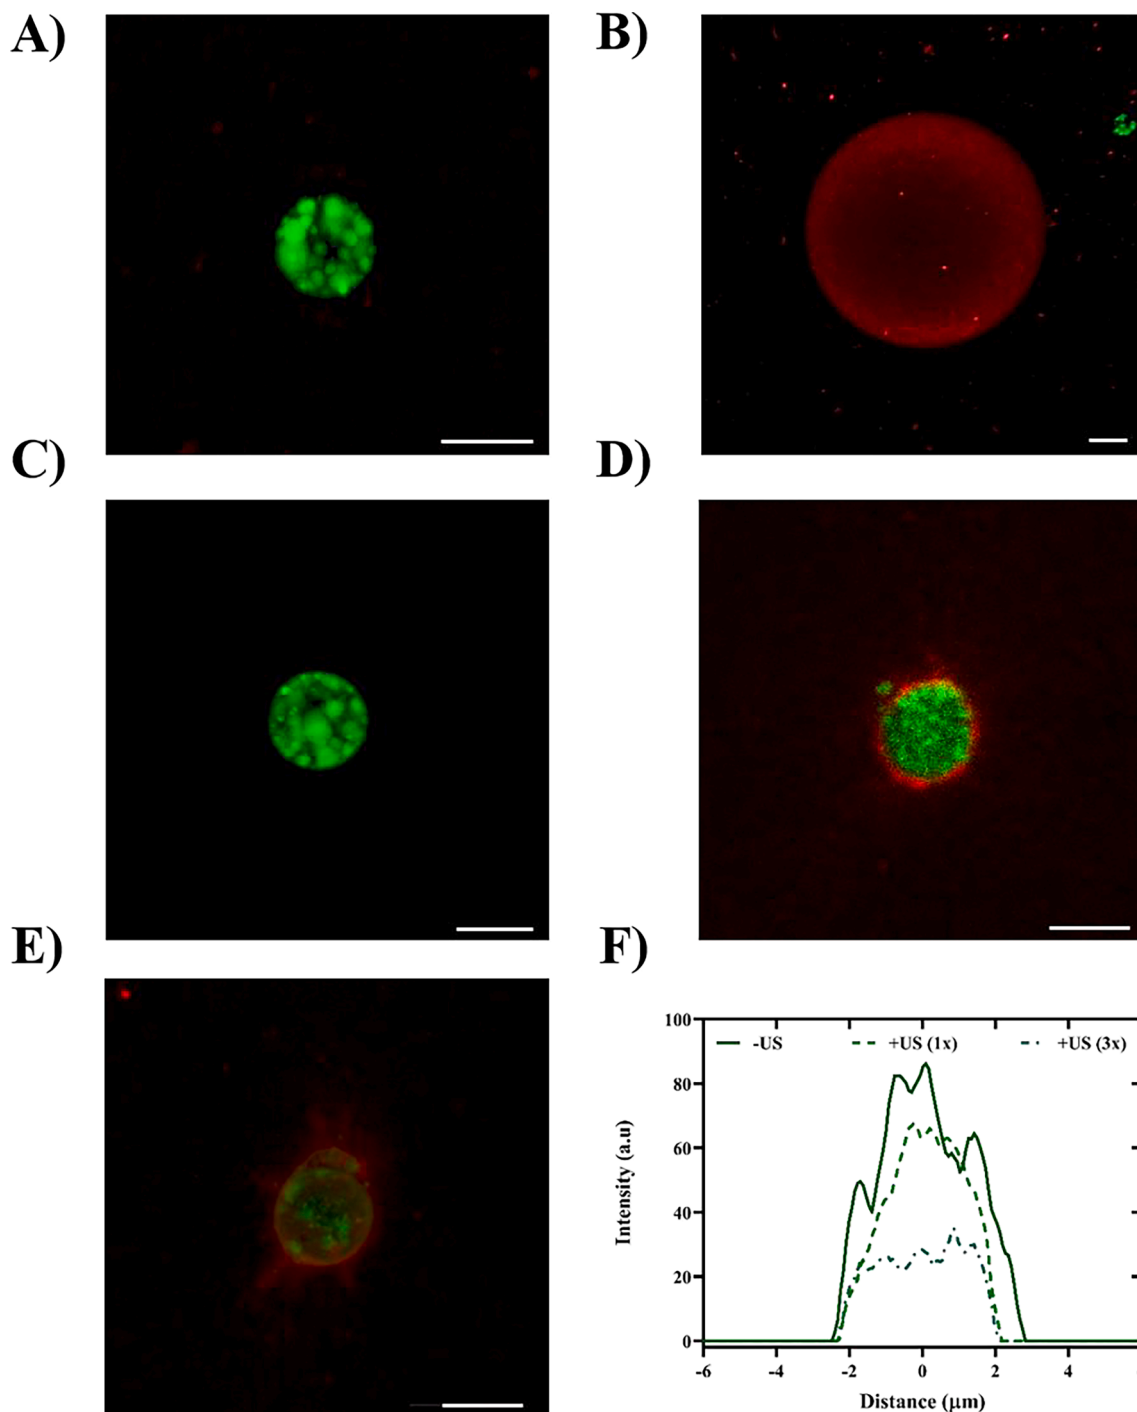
Acoustic droplet vaporization (ADV) in acoustically-responsive scaffolds (ARSs) resulted in stable bubble formation in sufficiently-sized perfluorohexane (PFH) emulsion and transient bubble formation in perfluorooctane (PFO) emulsion at 2.5 MHz (pulse duration: 5.4 μs). (A) Maximum intensity projection of confocal z-stacks of an ARS containing PFH emulsion. The fibrin matrix contained Alexa Flour 647-labeled fibrinogen (shown in red) while the phase-shift double emulsion contained Alexa Flour 488-labeled dextran (AF₄₈₈, shown in green). (B) ADV resulted in stable bubble formation in ARSs containing PFH emulsion. ARSs with PFO emulsion (C) before and (D) after ADV behaved differently (no stable bubble formation). Similar acoustic settings were used in (B) and (D). (E) Repeated ultrasound (US) exposures (3x) in ARSs with PFO emulsion resulted in more AF₄₈₈ release, thus indicating repeated vaporization and recondensation during US pulses. AF₄₈₈ intensity measurements, comparing payload release from PFO over multiple US exposures, is shown in F. Scale bar for all panels: 5 μm . (For interpretation of the references to colour in this figure legend, the reader is referred to the web version of this article.)
